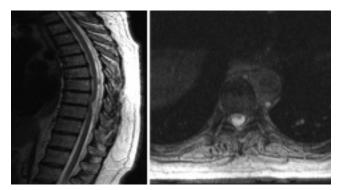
Preoperative MR imaging studies obtained in the thoracic spine of a 71-year-old woman who presented with Brown-Séquard syndrome and progressive myelopathy. Left: A sagittal T2-weighted image demonstrates a ventral spinal cord herniation at the level of T8–9. Right: An axial T2-weighted image shows ventral displacement of the thoracic spinal cord and a widened dorsal subarachnoid space.
